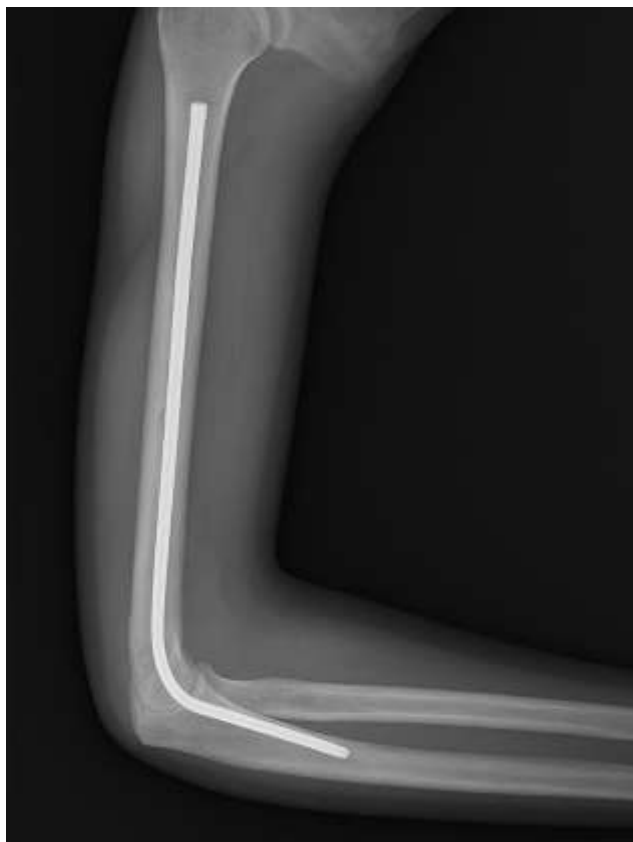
3-month follow-up X-ray showing complete union
